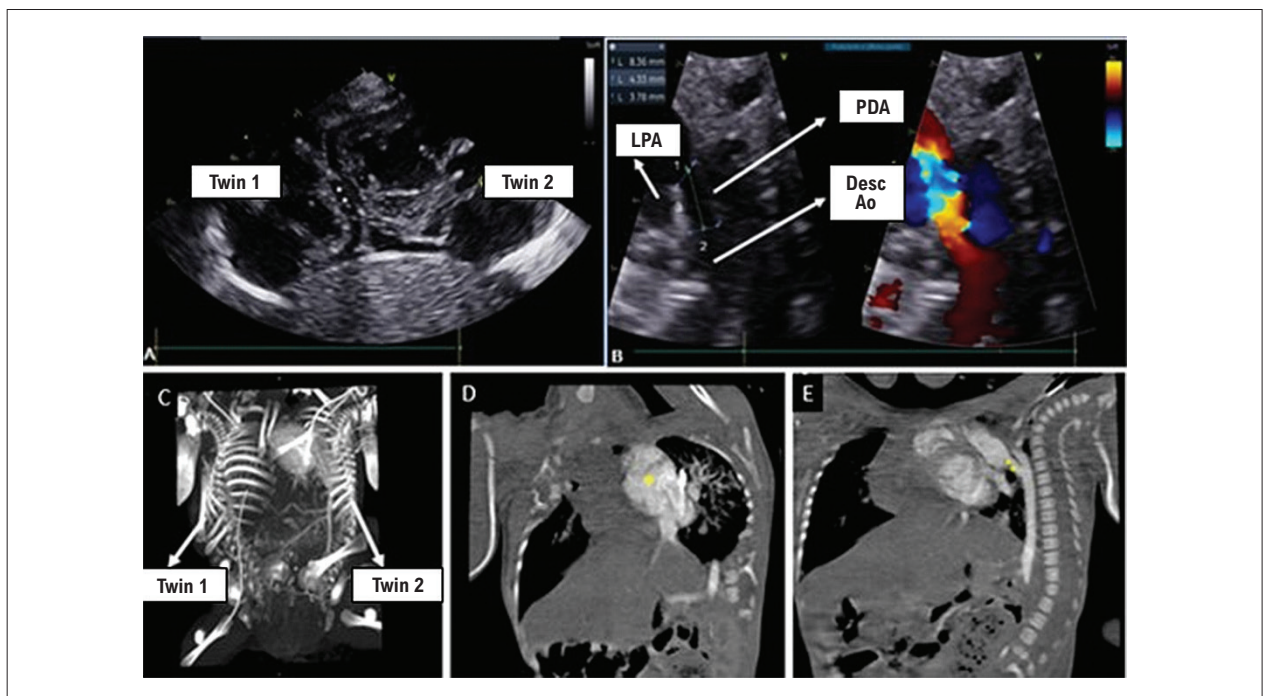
Complementary echocardiogram and tomography angiography. A) Echocardiogram showing 2 hearts sharing the same pericardium. B) Echocardiographic section identifying the following structures: descending aorta, left pulmonary artery, and persistence of the ductus arteriosus and its measurements, where 1 = pulmonary ampulla, 2 = aortic ampulla, and 3 = length. C) Tomography with bone reconstruction individualizing the twins. D) * Heart of the second twin. E)  Patent ductus arteriosus. Desc Ao: descending aorta; LPA: left pulmonary artery; PDA: persistence of the ductus arteriosus.
